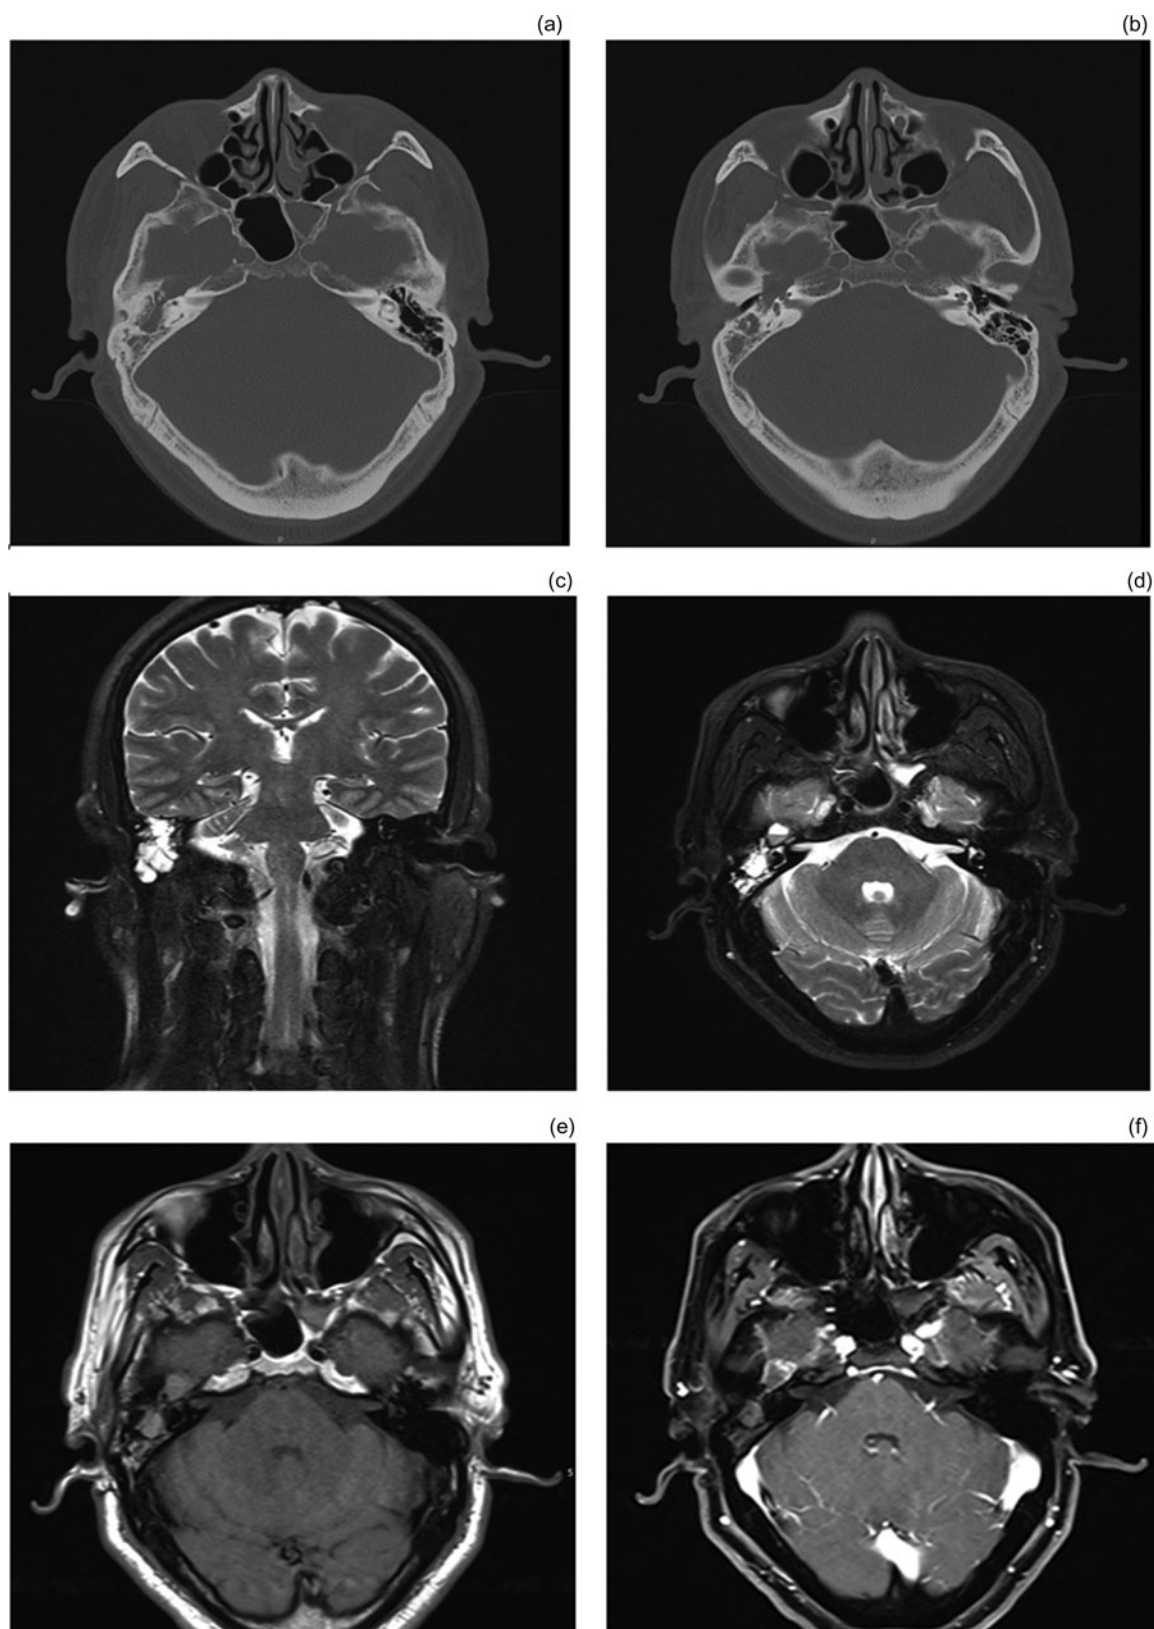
(a & b) Axial computed tomography images: a mass could be seen on the right skull base with compressive bone defects, involving the apical and middle turn of the right cochlea, tympanic cavity, and genu of the facial nerve. (c) Coronal and (d) axial T2-weighted magnetic resonance imaging (MRI) scans. (e) Axial T1-weighted MRI scan. (f) Axial T1-weighted MRI scan with contrast. The mass presented medium signals on T1-weighted MRI and high mixed signals on T2-weighted MRI with peripheral heterogeneous enhancement, presenting a 'soap bubble' pattern.
